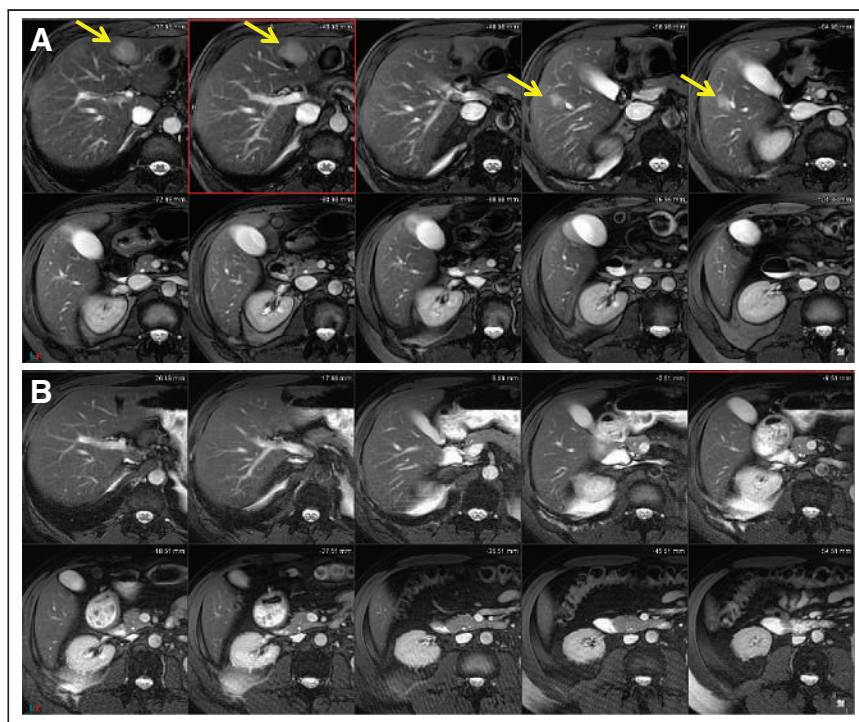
MRI of liver before (A) and after (B) treatment with 4 cycles of ^{212}Pb -DOTAMTATE in subject MAD4-02. Arrows point to liver metastases. Near-complete resolution of liver metastases is seen in B.
